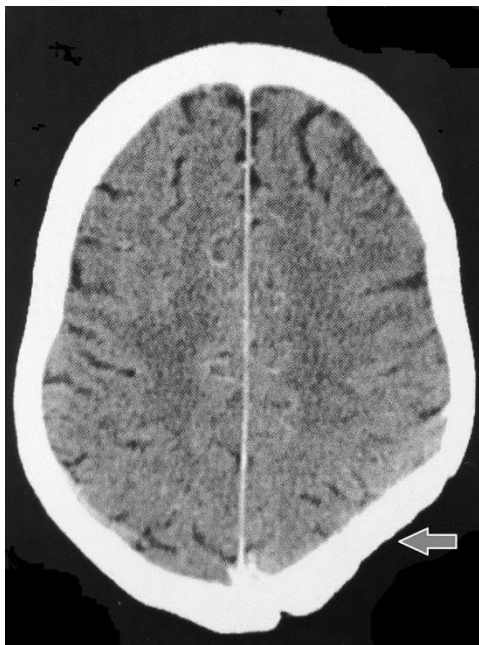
Preoperative brain CT. Bone plasty (red arrow), there is no tumor recurrence
